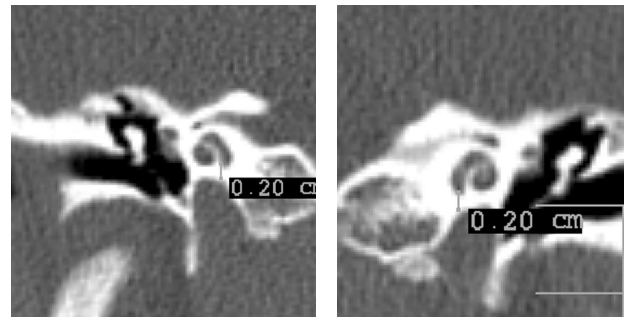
a and b: Coronal HRCT of temporal bone in a patient whose CCI measurement is the same on both sides (2mm).
